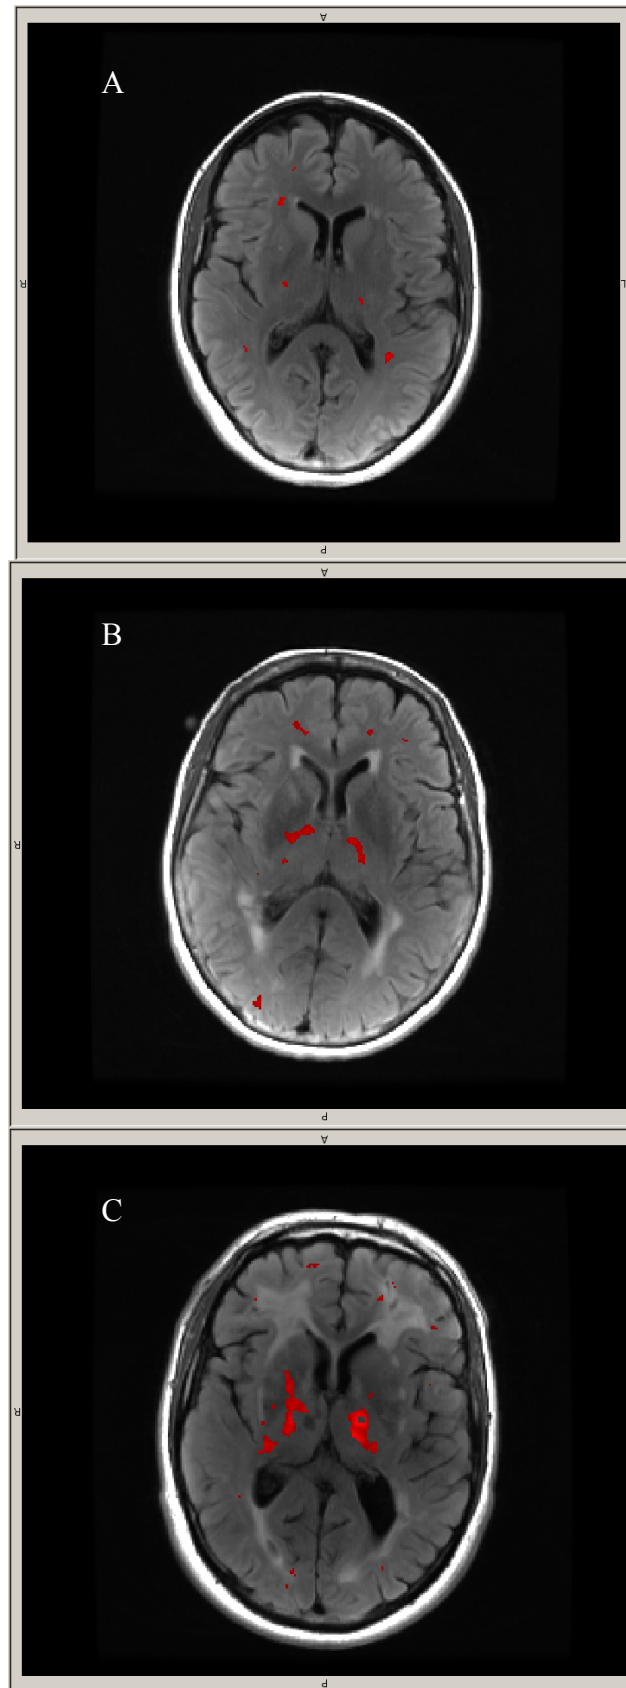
Example images of PK binding hotspots (red) overlaid onto T2 FLAIR scans. A) Control. B) Sporadic SVD. C) CADASIL.
